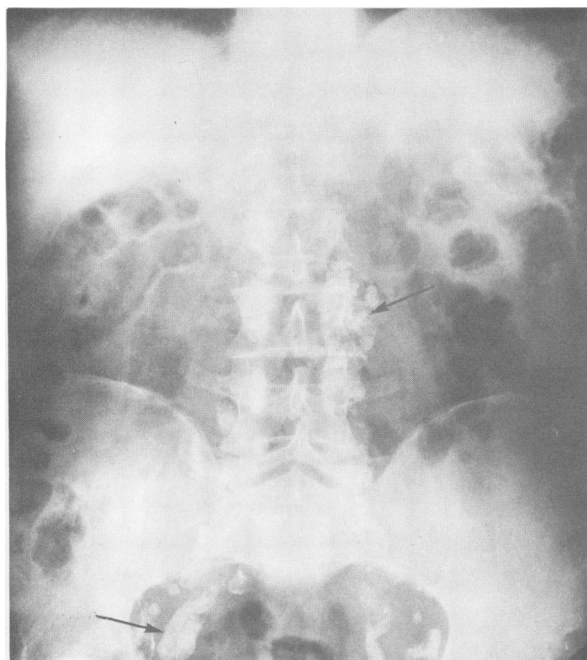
Arrows indicate large radiographically positive nodes not sampled at the time of the staging laparotomy.
